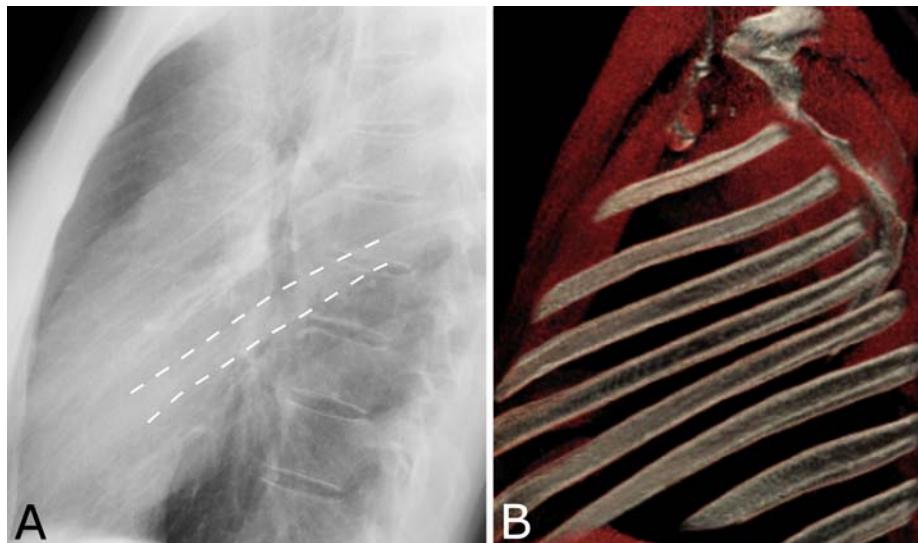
A. Lateral radiograph shows the course of the lateral ribs (outlined in white). *B.* Volume rendered CT scan shows the ribs as they are seen on a lateral radiograph. This view shows only one side (in this case, the left) but on the actual radiograph, the left and right ribs overlap. Notice that the ribs generally slop downward as they course from posterior (right side of the image) to anterior (left side of the image).
